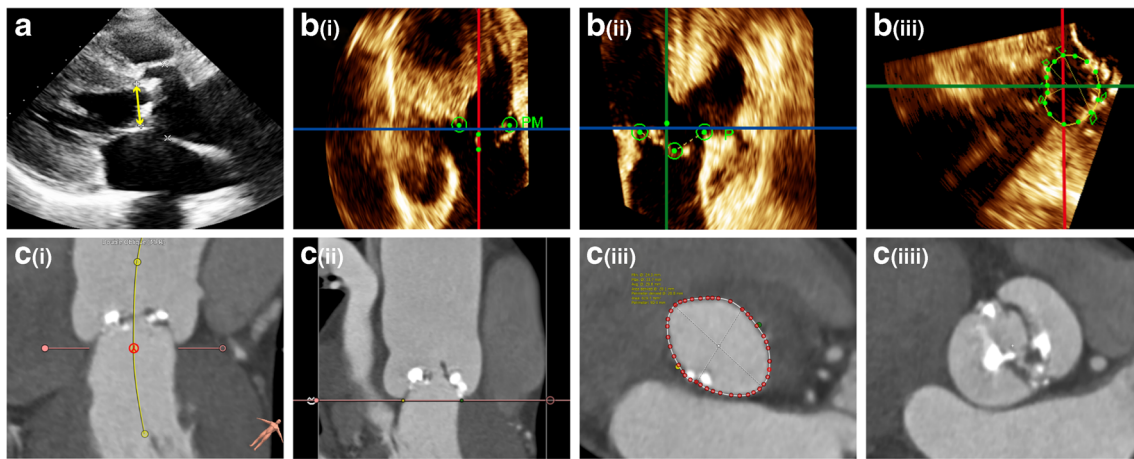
Measurement of aortic annulus diameter by 2DTTE, 3DTTE and CT. a Measurement of aortic annulus diameter by 2DTTE in the parasternal long-axis three-chamber view during mid-systole. b Stepwise approach to measurement of aortic annulus diameter by a 3D data set from 3DTTE: The transverse plane (blue plane) of the annulus is identified by alignment of the two orthogonal long-axis views (red and green planes). The hinge point of each individual aortic valve cusp is identified to establish the plane of the annulus. Four plots are placed on orthogonal long-axis images (i and ii) at the level of the annulus. Sixteen plots are adjusted (if needed) and confirmed. Measurement is performed on the short-axis image (iii). c Example of measurement of the aortic
